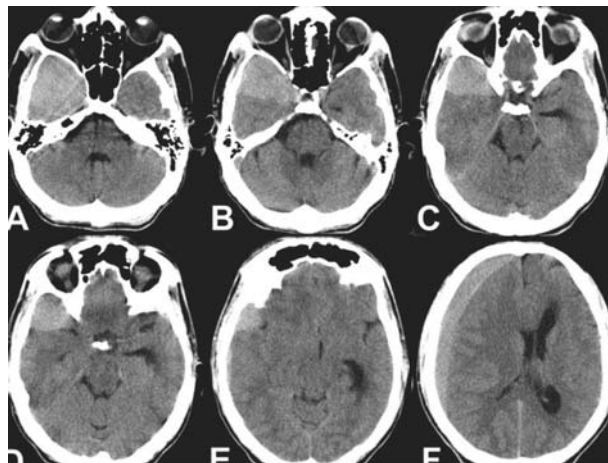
CT scan brain axial images showing crescentic hypo- and isodense fronto-parietal and biconvex temporal-sub temporal collections of chronic subdural hematoma
